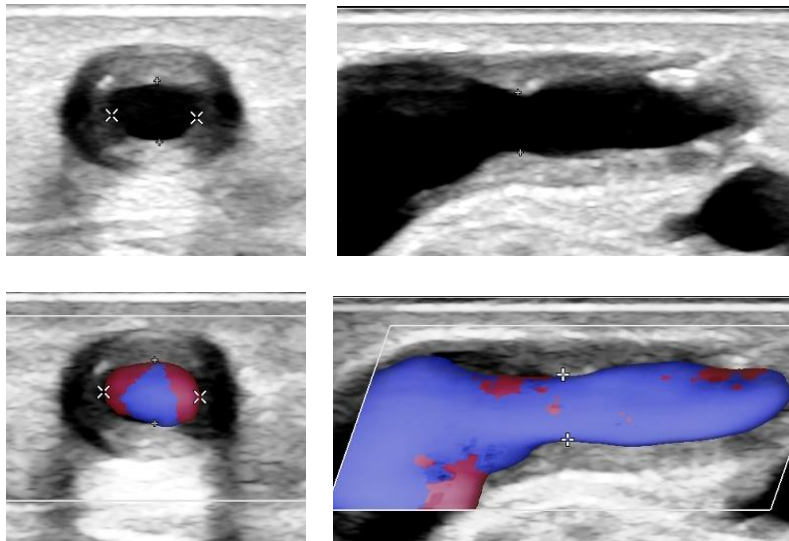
Example case subject with B-mode transverse (top left), B-mode longitudinal (top right), power Doppler transverse (bottom left) and power Doppler longitudinal (bottom right). The transverse views contain both an antero-posterior measurement and medial-lateral measurement.
